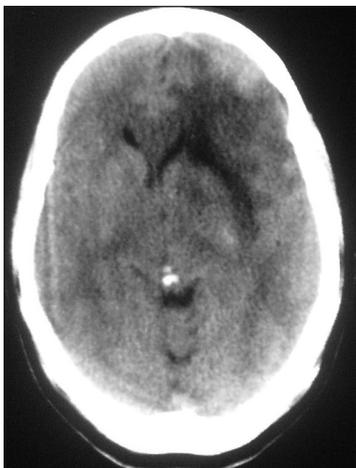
CT Brain showing glioma
